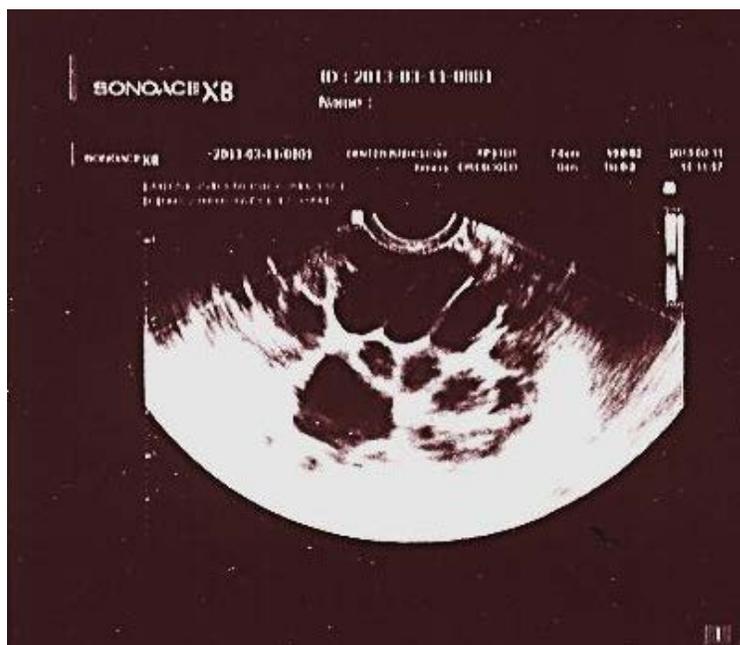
Pelvic sonography: Multicystic right adnexal mass
